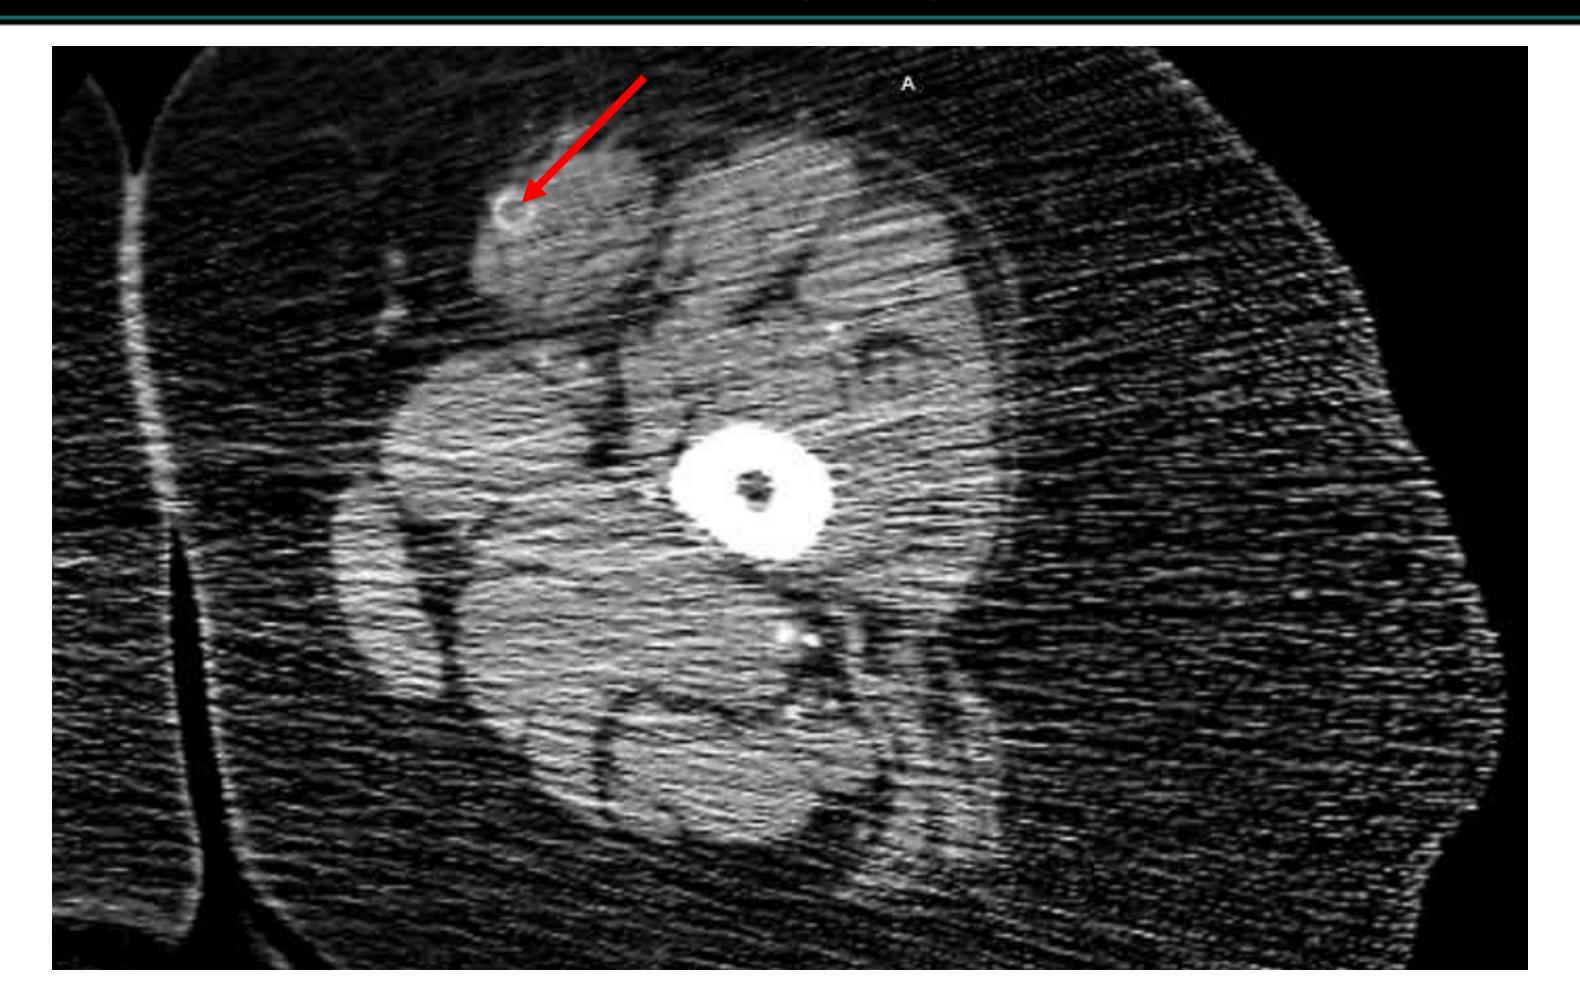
CT Angiogram Lower Extremity, arrow pointing to femoral artery occlusion
